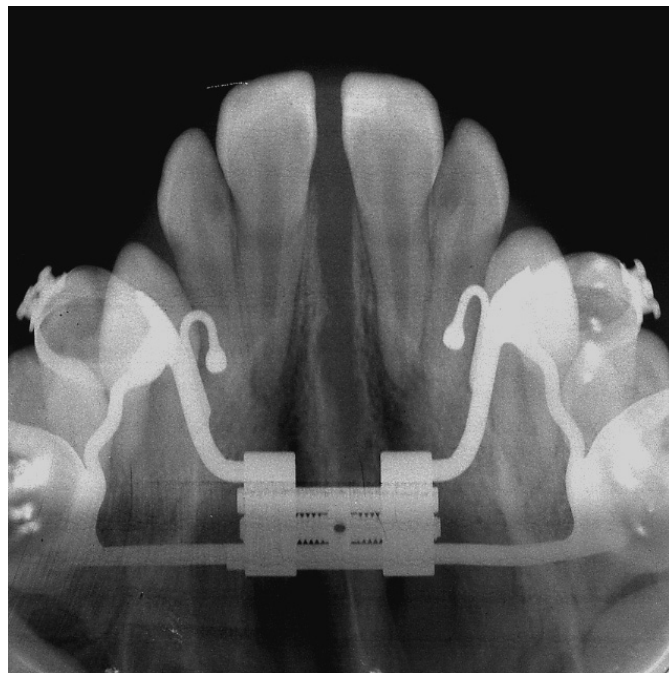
Maxillary occlusal radiograph of patient after active RME showing separation of midpalatal suture
